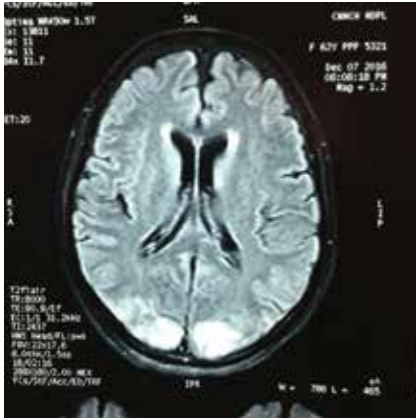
MRI brain T2 flair showing bilateral occipital hyper intensities
